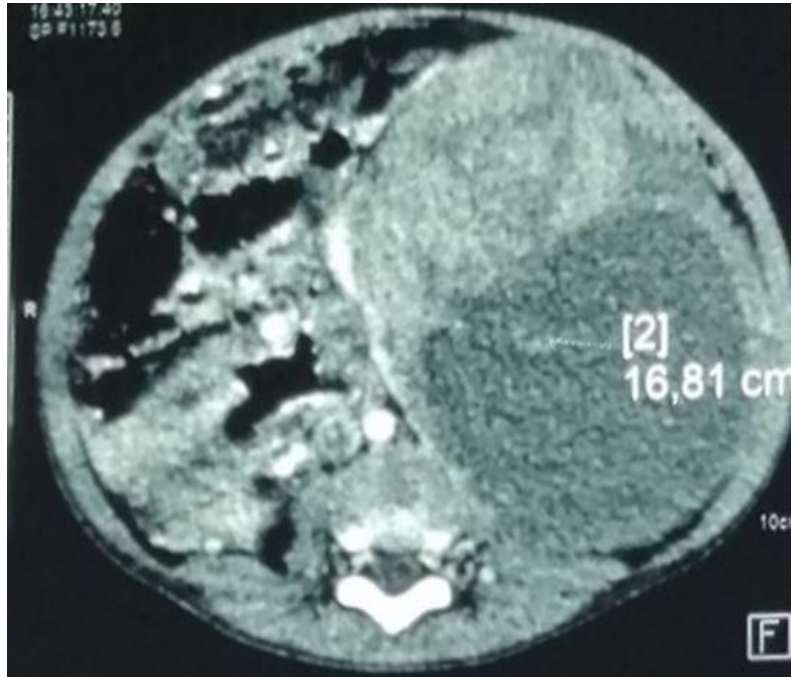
Preoperative CT scan showing the left renal nephroblastoma (arrow).
